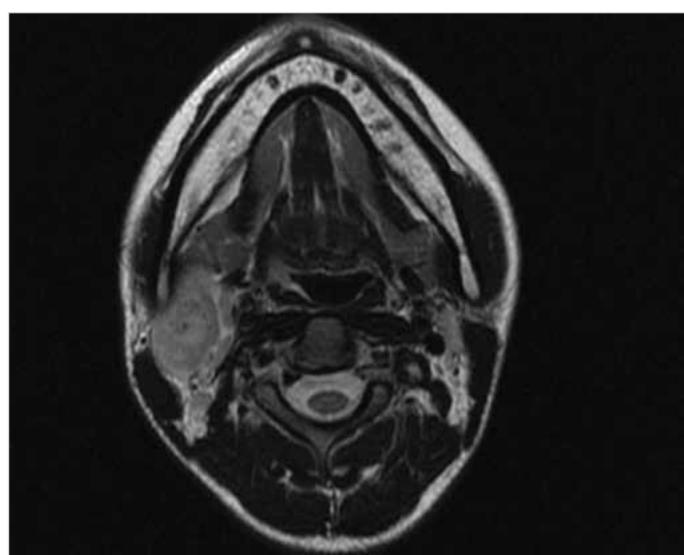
Magnetic Resonance Imaging – a pathologic lesion sized 26 x 22 x 17 mm was observed in the posterior cervical space.
